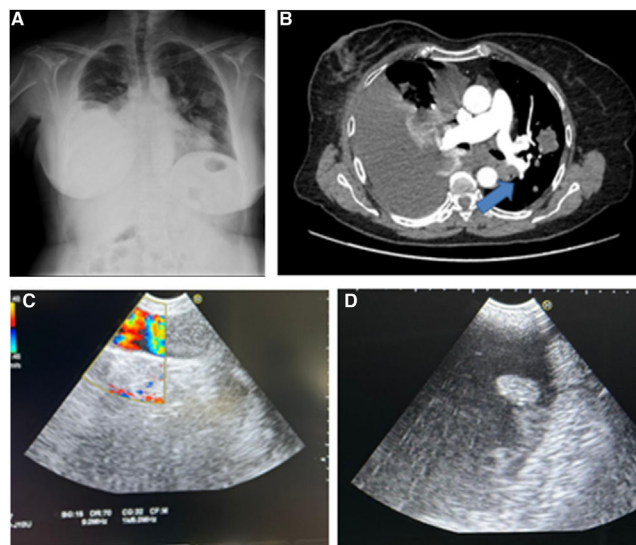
(A) Postero-lateral chest X-ray showing right pleural effusion along with contralateral nodular images. (B) Axial CT scan of the chest demonstrating pleural effusion along with an adenopathy cluster infiltrating the inferior pulmonary vein (arrow) and contralateral nodule. (C) Doppler ultrasound image at the level of the pulmonary vein showing an endoluminal vascular lesion with Doppler signal around it. (D) Ultrasound image revealing an implant at the level of the left cardiac cavity.
